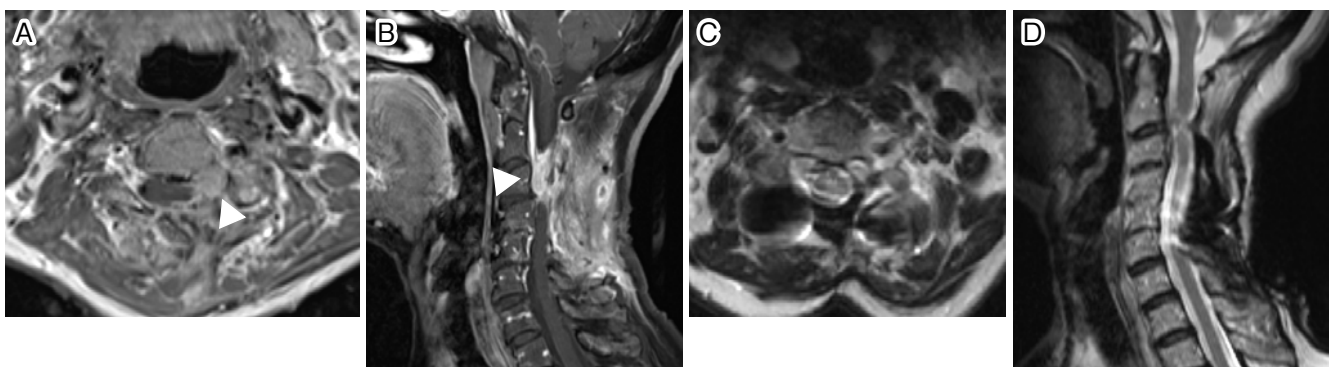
A, B: 3-month postoperative axial (A) and sagittal (B) enhanced T1 magnetic resonance images. C, D: Axial (C) and sagittal (D) T2 magnetic resonance images 3 years after the second surgery.
